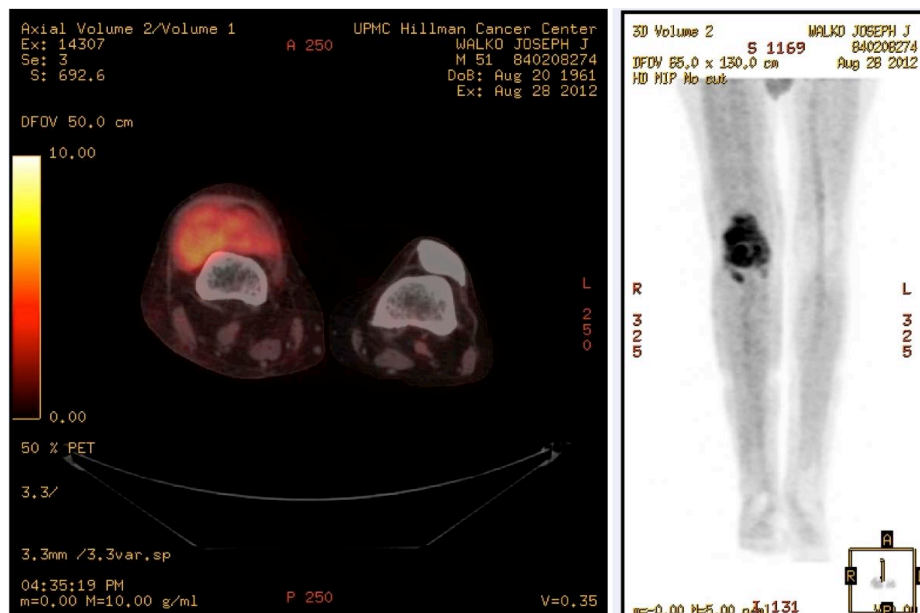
PET-CT scan of right knee: PET-CT scan demonstrated right knee mass with increased FDG uptake.
